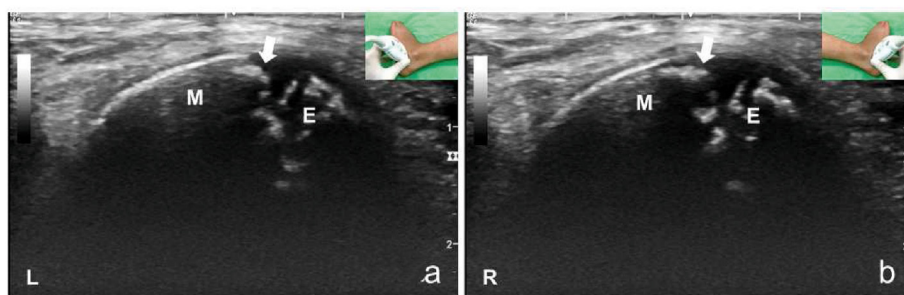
Ultrasonographic image of the growth plates of the (a) left and (b) right calcanei in a longitudinal view of the foot of the 10-year-old boy. This image shows the hyperechoic outline of the meta-epiphyseal regions of the bones (arrows), with an incompletely ossified epiphysis (E). The metaphysis (M) can be observed, with comparable widening of the non-closed growth plates at bilateral calcanei.
